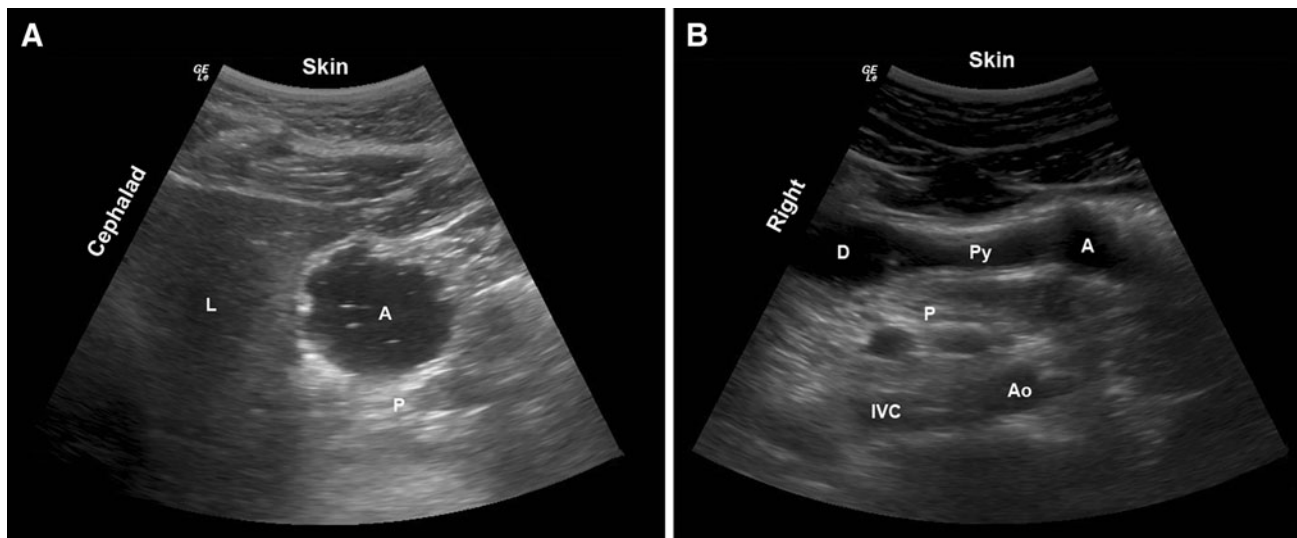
A Sagittal sonogram of the gastric antrum immediately following ingestion of 200 mL of clear fluid (“starry night” appearance) A = antrum; L = liver; P = pancreas. B Axial
